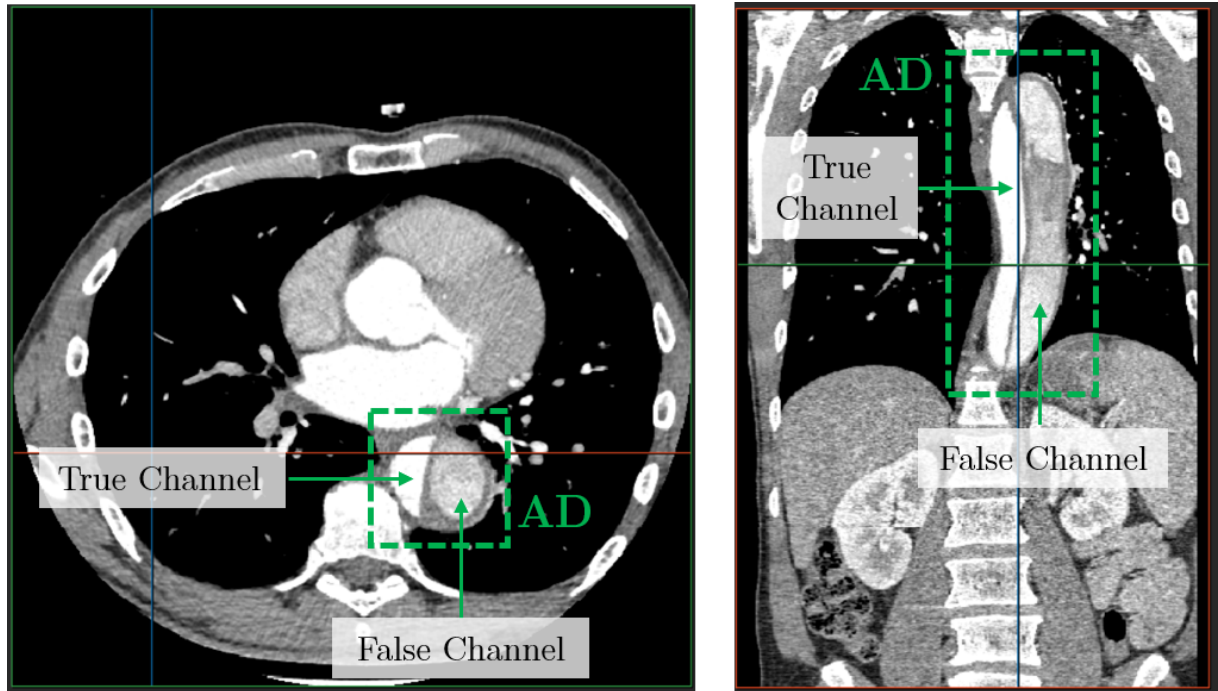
CT scan with (Left) the transverse plane and (Right) the frontal plane of the thoracic region for patient with AD. True and false lumen are indicated on the aorta.
